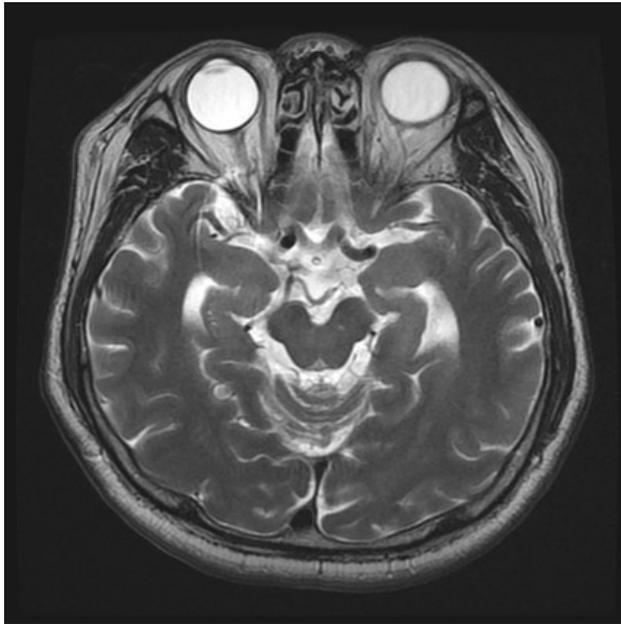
Follow-up magnetic resonance imaging demonstrating that the size of the amygdala has decreased compared with that depicted in previous images.
